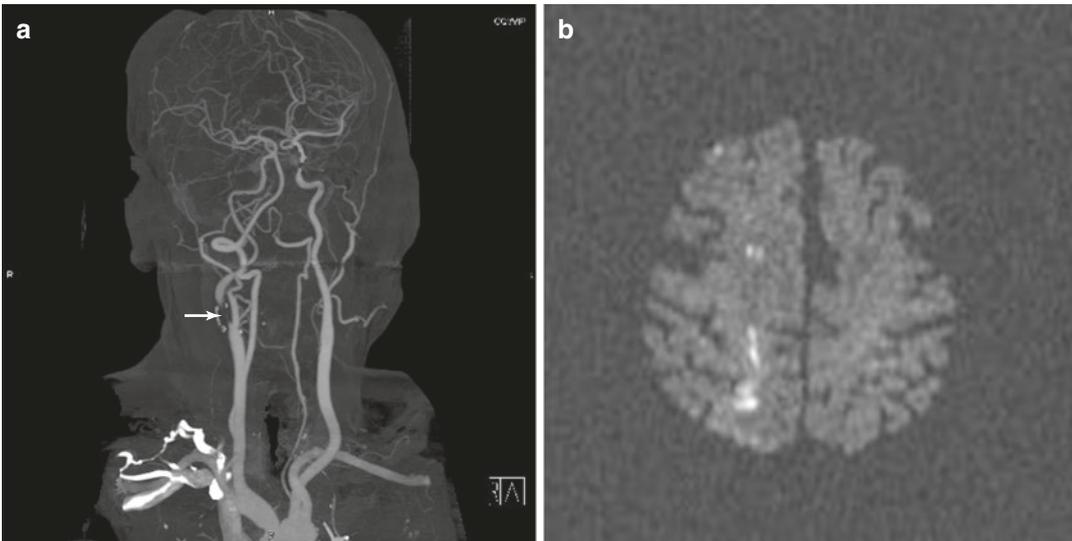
Hemodynamic infarct. (a) Severe stenosis at right proximal ICA on CT angiography. (b) acute linear infarct of frontoparietal cortex on diffusion-weighted image
